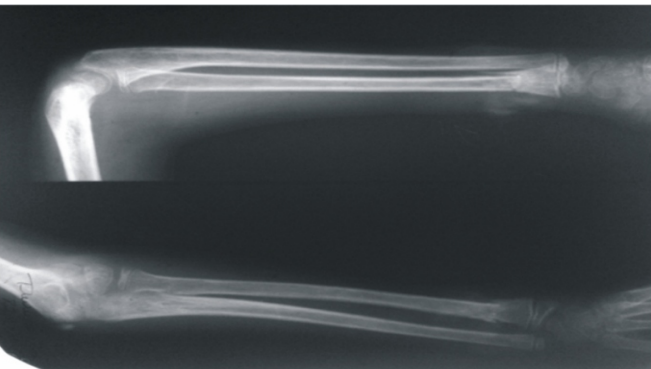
Clinical Photo and pre-op X-ray
